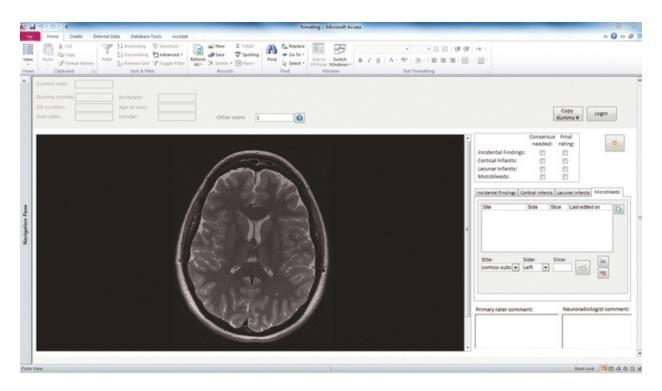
Screenshot of in-house developed database to register incidental findings on brain MRI. In the *upper row*, the participant's basic characteristics will be filled out (e.g., scan date, date of birth). In the *left screen*, the scan will be displayed. The fields on the *right side* can be used to characterize potential incidental finding
